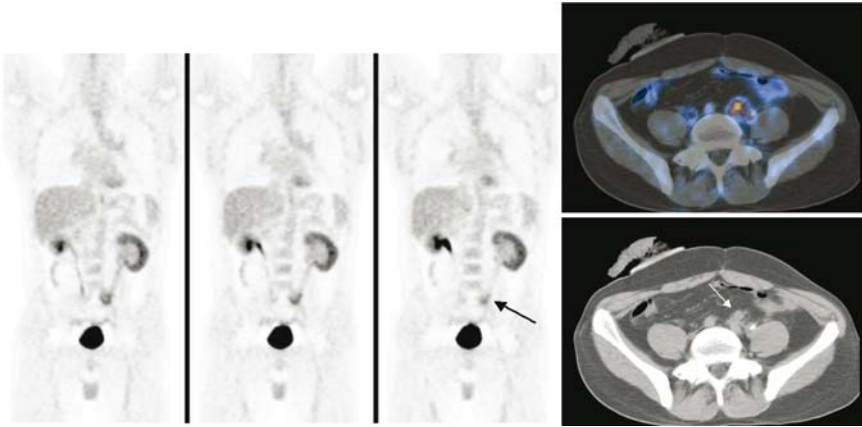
Precise characterization of increased ^{18}F -FDG uptake and retrospective lesion detection on CT, after PET/CT. The patient is a 35-y-old man, 22 months after treatment of colon cancer, with negative high-resolution contrast-enhanced CT and normal levels of serum tumour markers, referred for PET scan for assessment of pelvic pain. The coronal PET images (left) show area of increased ^{18}F -FDG uptake in left pelvic region (arrow), interpreted as equivocal for malignancy, possibly related to inflammatory changes associated with ureteral stent or to physiological bowel uptake. Hybrid PET/CT (right) transaxial image (top) precisely localized uptake to soft-tissue mass adjacent to left ureter, anterior to left iliac vessels. Mass (arrow) was detected only retrospectively on both diagnostic CT and CT component of hybrid imaging study (bottom). Patient received chemotherapy, resulting in pain relief and decrease in size of pelvic mass on follow-up CT. Reprinted with permission from ref.¹⁰⁹
